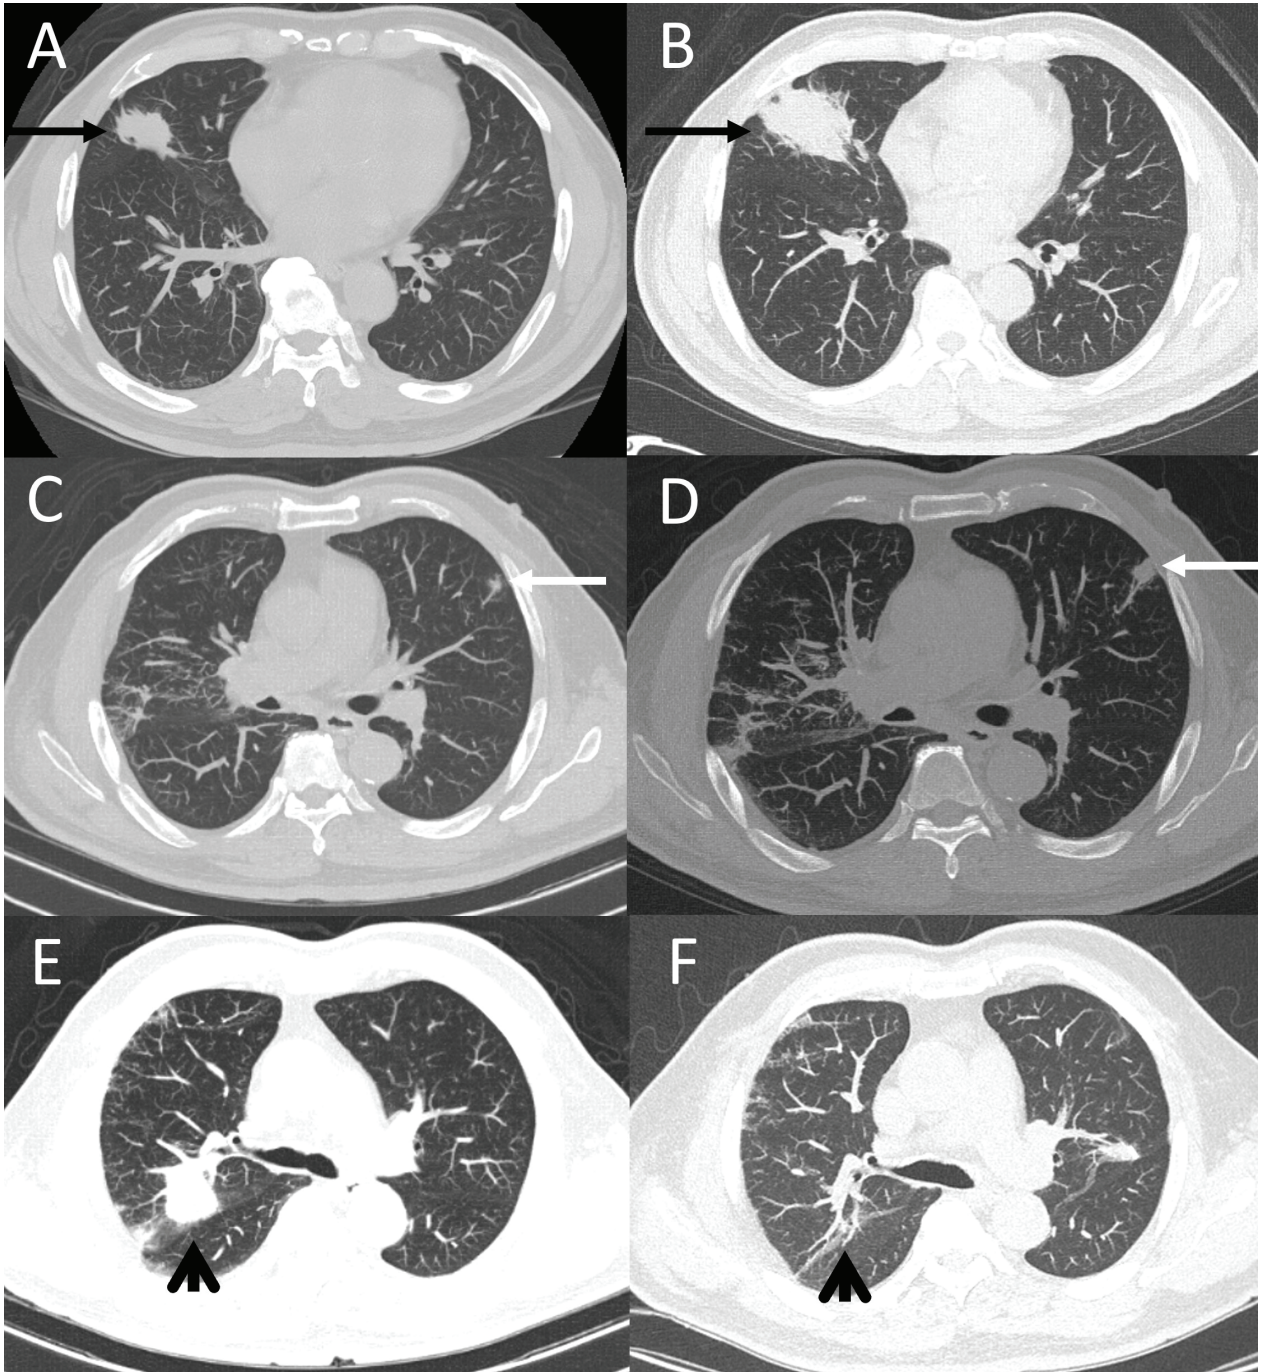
Serial chest CT scan. A, Feb. 2014: right middle lobe (RML) irregular mass-like lesion of the lung with adjacent minor fissure retraction (black arrow). B, Jul. 2015: progressive RML spiculated mass. C, Sep. 2017: a new subsolid nodule over the left upper lobe (LUL) of the lung (white arrow) during follow-up. D, Jan. 2018: slow progression of the LUL subsolid nodule with suspicious subtle slow progression of the bilateral lung acinar nodules and mediastinal lymph nodes. E, Aug. 2022: progressive bilateral lung metastasis and a right upper lobe (RUL) nodule (arrowhead) before crizotinib and entrectinib treatment. F, Mar. 2023: regressive change in the RUL metastatic nodule after crizotinib (in Oct. 2022) and entrectinib (since Dec. 2022) treatment.
